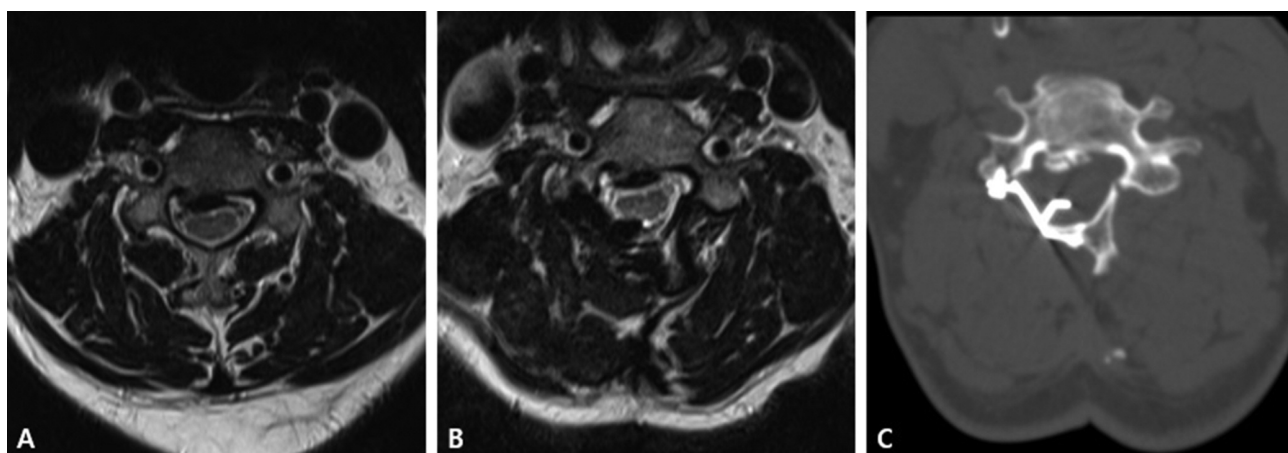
(A) Spinal cord compression due to OPLL on the pre-operative magnetic resonance image. (B) Spinal cord compression and subtle signal intensity change of spinal cord were identified on the magnetic resonance image. (C) The wide lamina shelf of plate protruded into the epidural space on computed tomography image.
